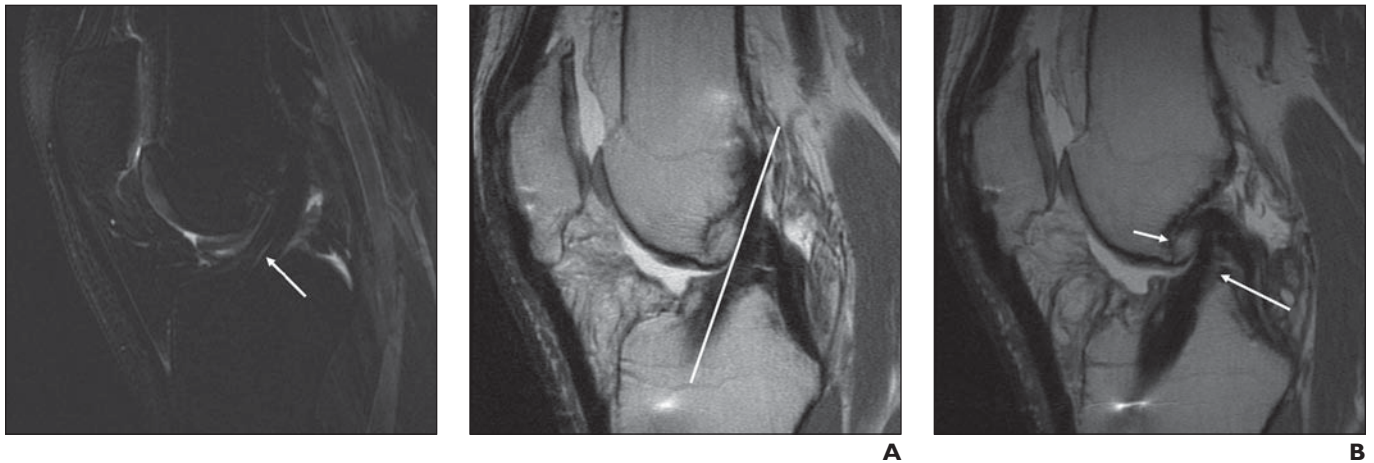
Sagittal T2-weighted fat-suppressed MR image of 25-year-old man who presented for follow-up imaging after anterior cruciate ligament reconstruction. Image shows normal appearance of doubled semitendinosus and gracilis tendon graft: Graft is of low signal with linear areas of increased signal (arrow), representing fluid tracking between strands of graft.
